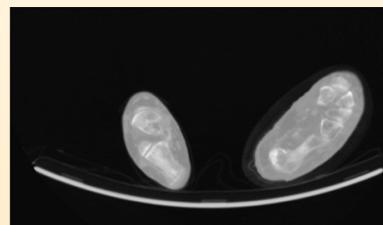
CT. Focal area of soft tissue swelling to left heel. Does not appear to extend to the underlying calcaneus.
